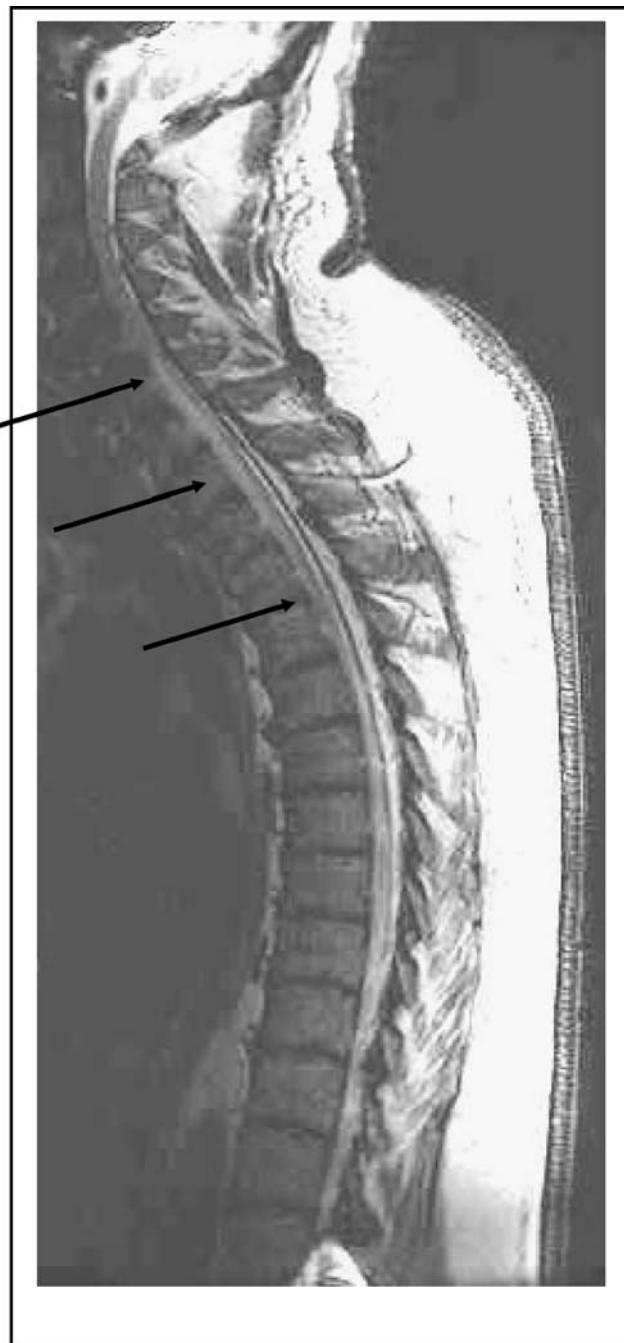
Sagittal T2-weighted sequence MRI with hyperintense lesion of the anterior spinal cord from C6-T3, consistent with infarction (arrows).
